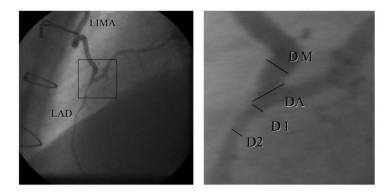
An X-ray image of an anastomosis using coronary angiography. The graft is the left internal mammary artery (LIMA) and the target coronary artery is the left anterior descending coronary artery (LAD). DM, DA, D1, and D2 represent diameters of the graft, anastomotic orifice, toe site, and native coronary artery in the toe of the anastomosis respectively. [46]
